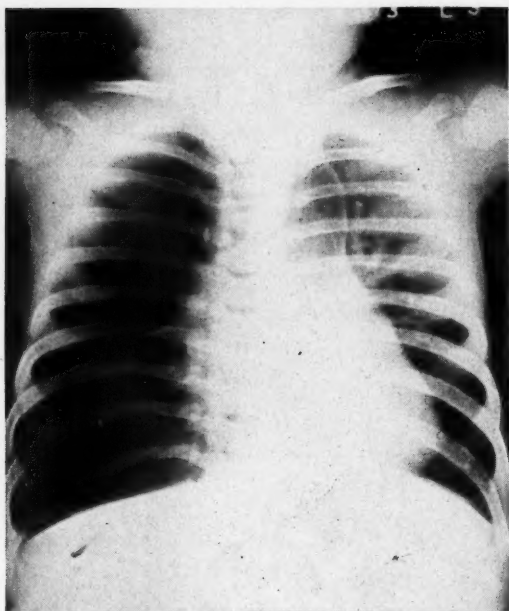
(Case 5) A two and a half year old boy who tired easily but a lesion was not discovered until nine months of age when an x-ray was taken. There was marked lung field translucency with compression of the heart and mediastinum to the left. Septa were present. Diagnosis: cyst. Surgical and pathologic diagnosis: congenital cysts.
